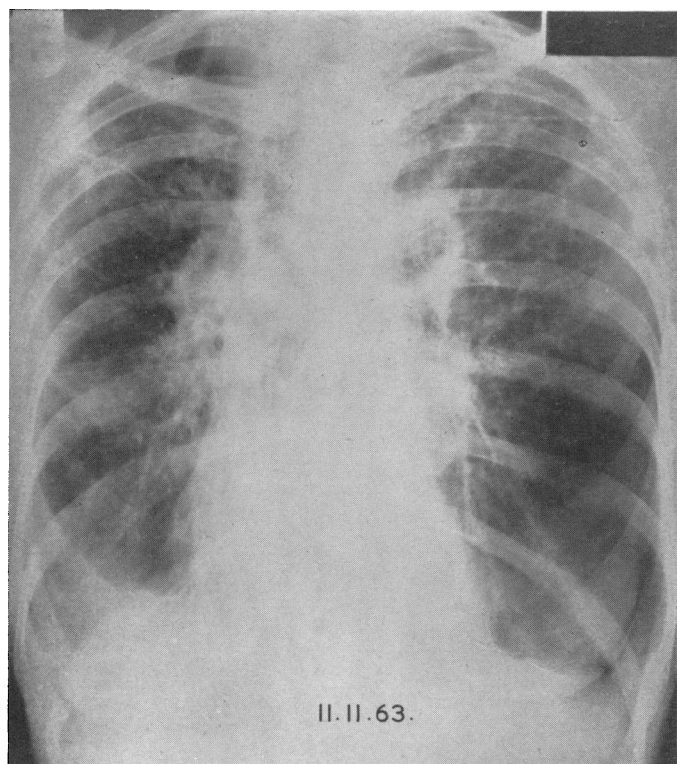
Postero-anterior radiograph (11 November 1963) showing widespread pulmonary fibrosis, particularly in the right lung and left upper zone, with displacement of the mediastinum to the right.
